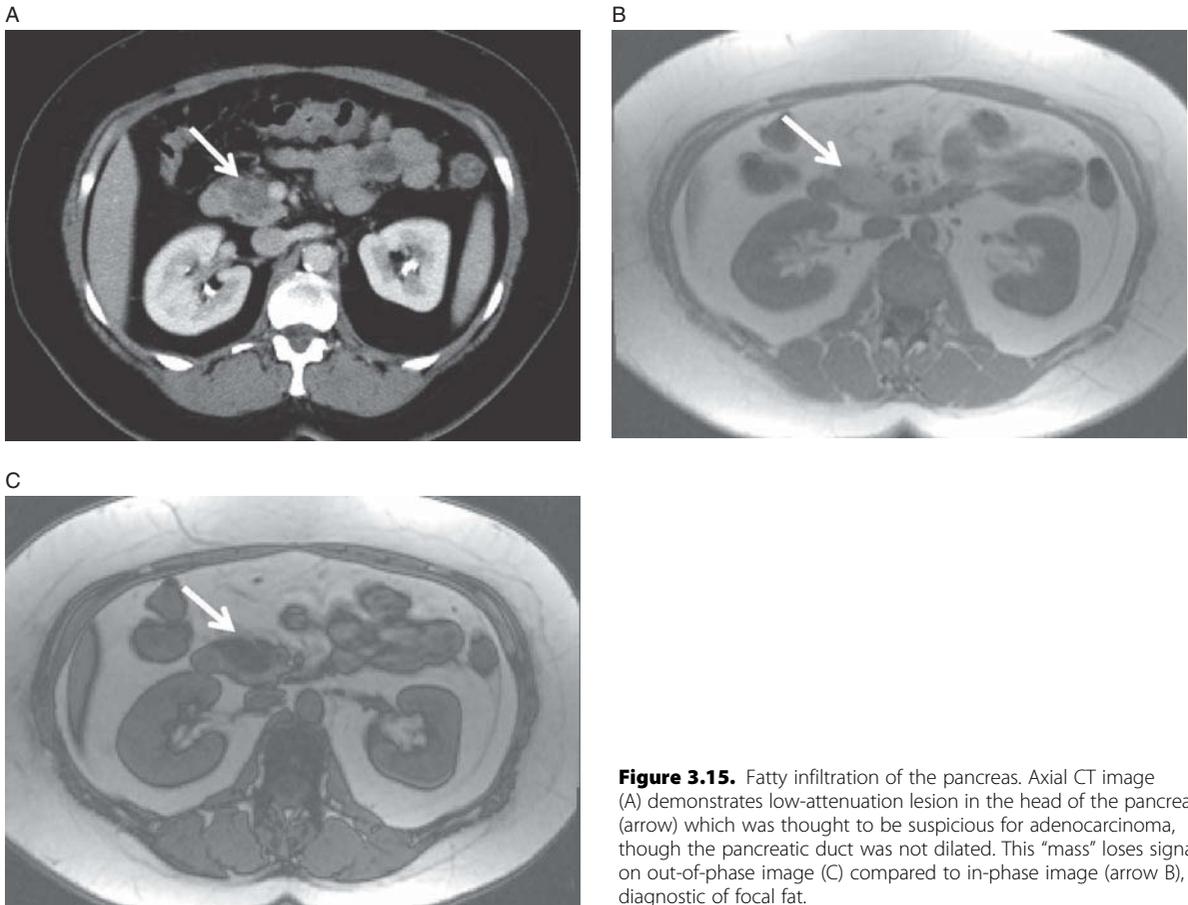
Fatty infiltration of the pancreas. Axial CT image (A) demonstrates low-attenuation lesion in the head of the pancreas (arrow) which was thought to be suspicious for adenocarcinoma, though the pancreatic duct was not dilated. This “mass” loses signal on out-of-phase image (C) compared to in-phase image (arrow B), diagnostic of focal fat.
